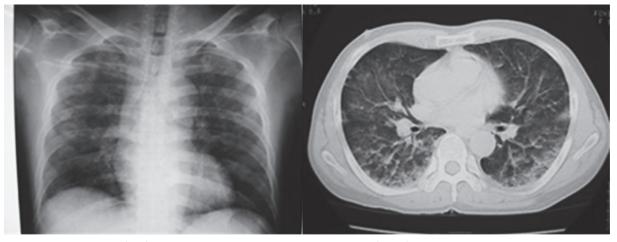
Chest X-ray (left) shows ground-glass opacity and CT (right) shows ground-glass opacity with bronchial dilatation
